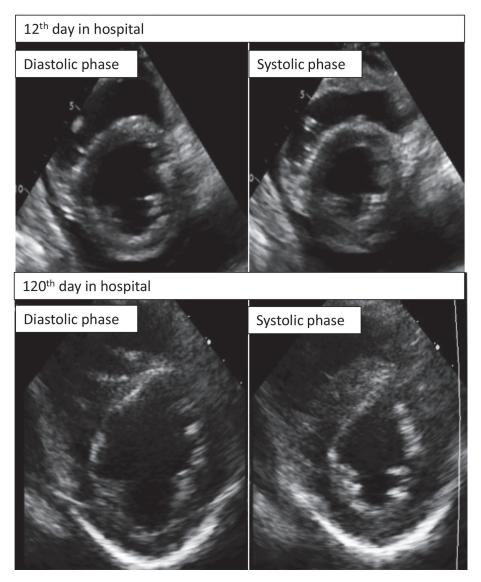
Clinical course of cardiomyopathy (echocardiogram)
